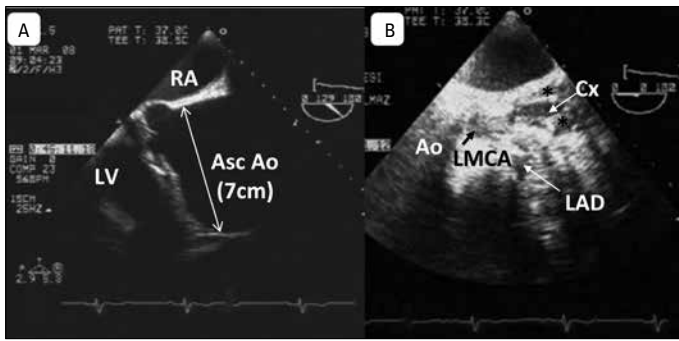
Parasternal long axis view showing aneurysmal dilatation of the aortic root (A), transesophageal short axis view showing proximal left main, left anterior descending and circumflex coronary arteries with partial thrombosis (asterisks) of the lumen (B)
